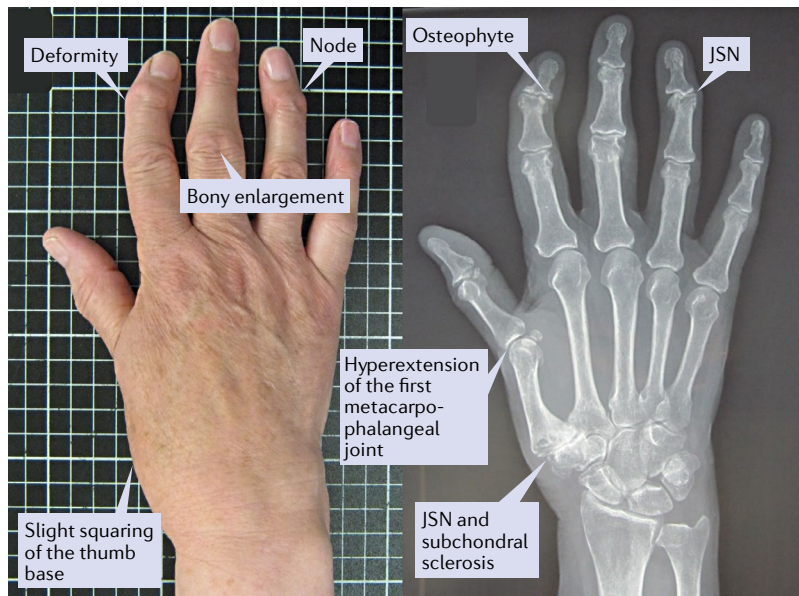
Features of hand osteoarthritis. A photographic image of an individual's hand showing squaring of the thumb base and bony enlargement, nodes and deformity of the interphalangeal joints and the corresponding radiograph displaying osteophytes, joint space narrowing (JSN) and subchondral sclerosis at the thumb base and interphalangeal joints are provided.
